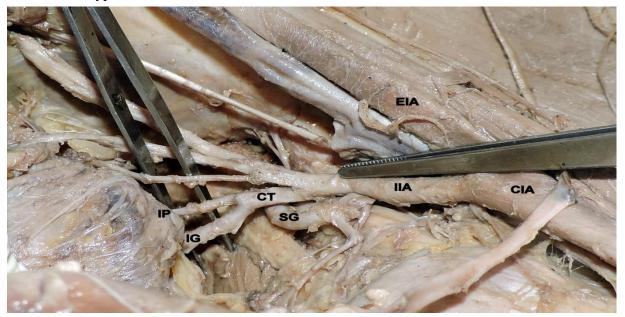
Right pelvic half shows type Ia Adachi's classification—superior gluteal artery arises separately from internal iliac artery and a common trunk (CT) for inferior gluteal artery and internal pudendal artery divides proximal to the pelvic floor. IIA: internal iliac artery; IG: inferior gluteal artery; SG: superior gluteal artery; IP: internal pudendal artery.
